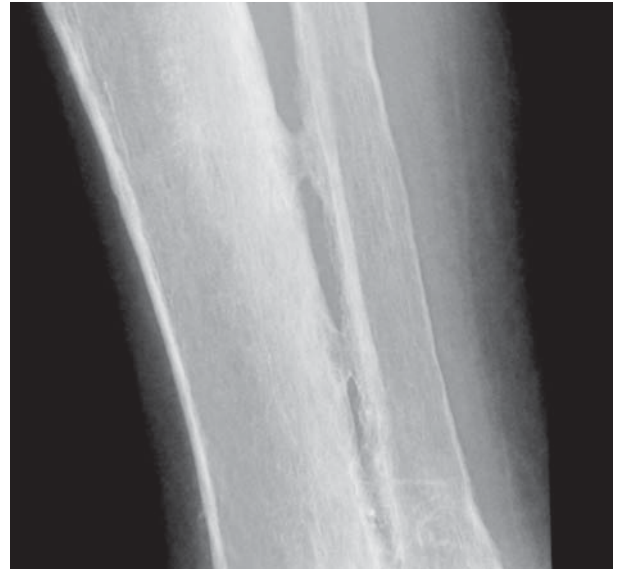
X-ray of the left calf: pronounced periosteal deposits on the tibia and fibula with bone bridge formation
